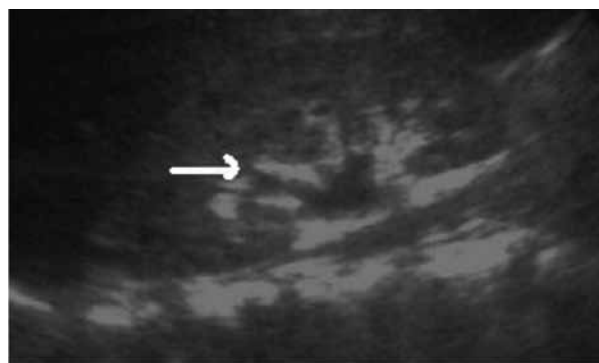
Transaxial ultrasound image shows a mild separation of the right central renal echo-complex (arrowed)
